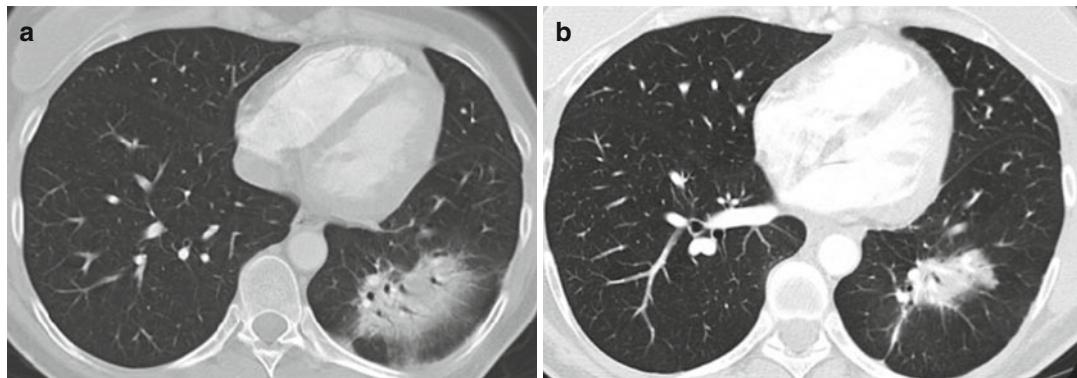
CT scan of the lung 4 (a) and 23 months (b) after stereotactic irradiation of a lung carcinoma in the left lower lobe. Demarcation of a diffuse opacification of the irradiated lung parts with a positive air bronchogram in terms of a typical radiation pneumonitis. The lung carcinoma cannot be differentiated anymore. In the further
